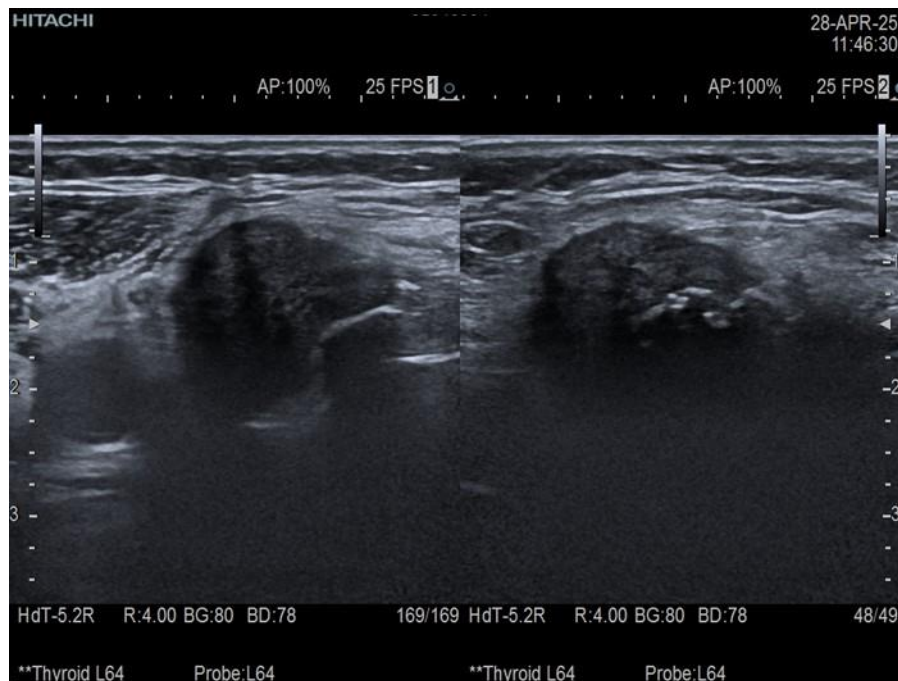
Ultrasound image of the markedly hypoechoic pathological formation in the right thyroid lodge – transverse plane
